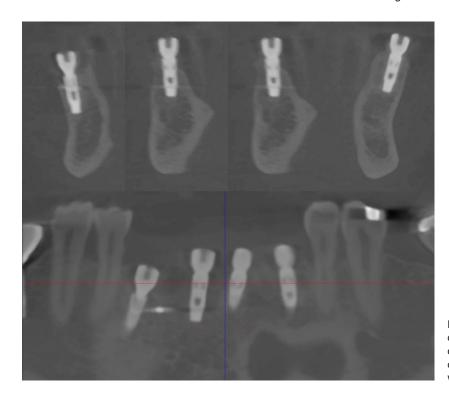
Post-operative CBCT of implant placement. CBCT view confirms the correct positioning of the four implants in mature and well-structured bone.
